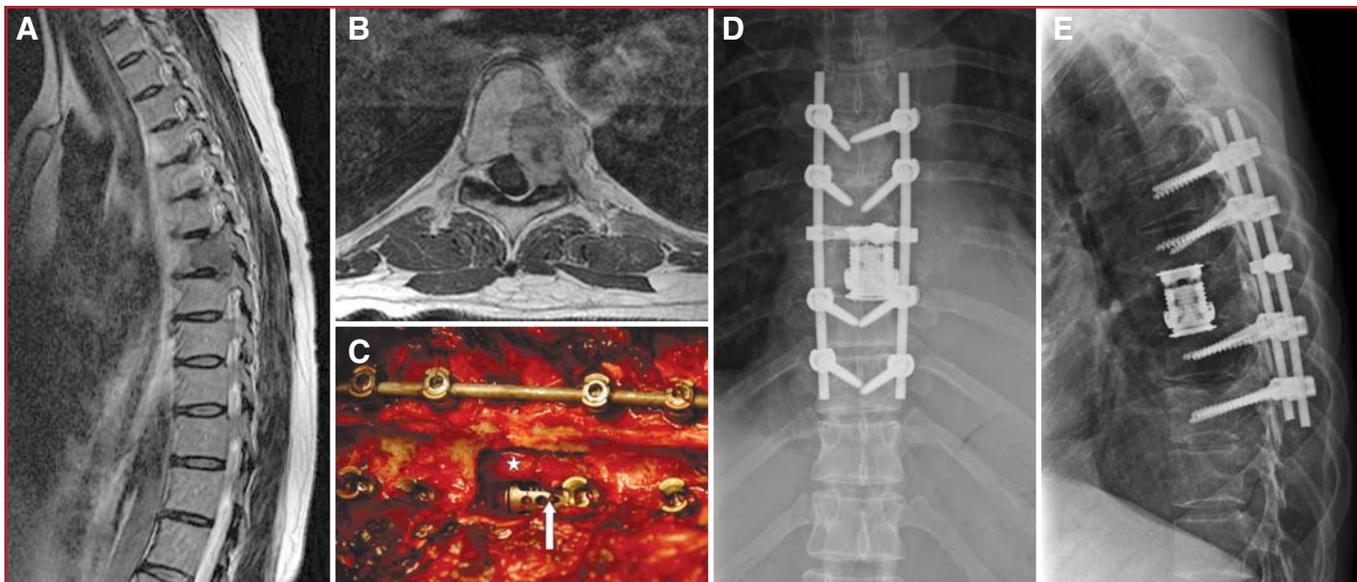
A 38-year-old woman with solitary spinal metastasis of leiomyosarcoma. Sagittal T2-weighted (A) and axial T1-weighted (B) magnetic resonance imaging scans showing posterolateral located metastasis of T7. Left-sided costotransversectomy and partial corpectomy were performed, followed by posterolateral insertion of VLIFT and pedicle screw fixation at
